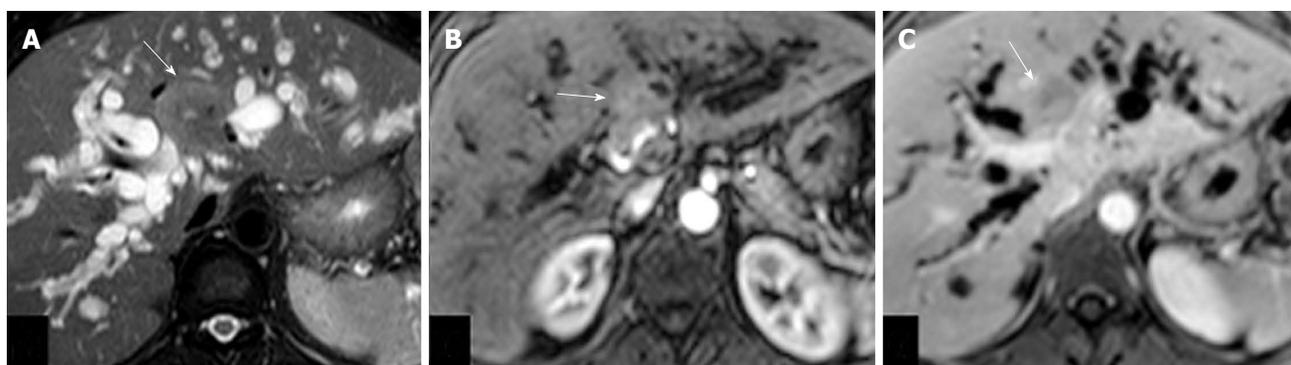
Case of nodular type of hilar cholangiocarcinoma. A: Axial T2-weighted magnetic resonance image show hypointense hilar mass (arrow) with biliary dilatation; B and C: Axial T1-weighted magnetic resonance images in arterial (B) and venous (C) phases showing mildly enhancing ill-defined mass lesion (arrow) encasing right hepatic artery and left portal vein.
